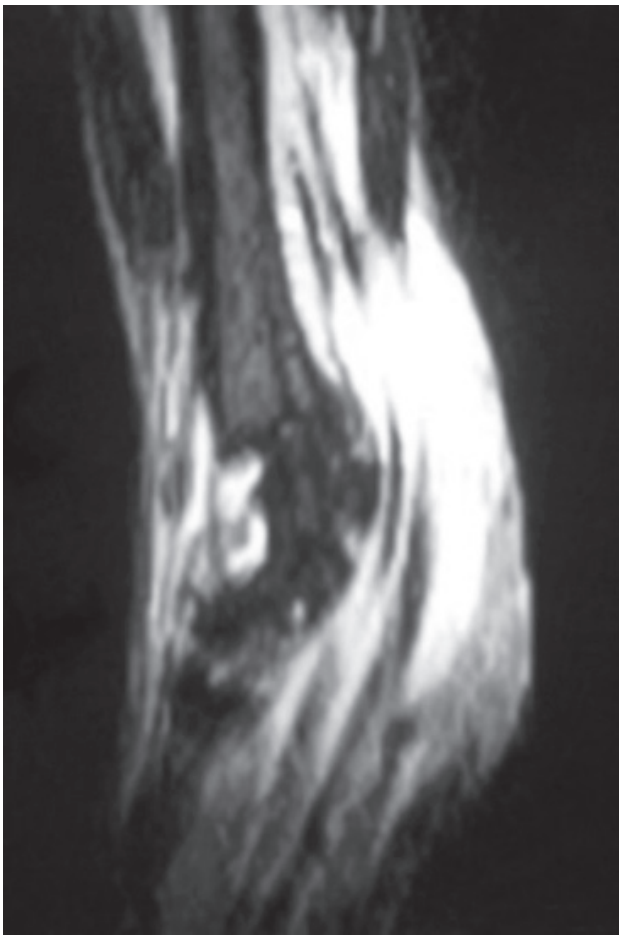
The magnetic resonance imaging showed increased intensity around the flexor tendons suggesting inflammatory infiltration.
